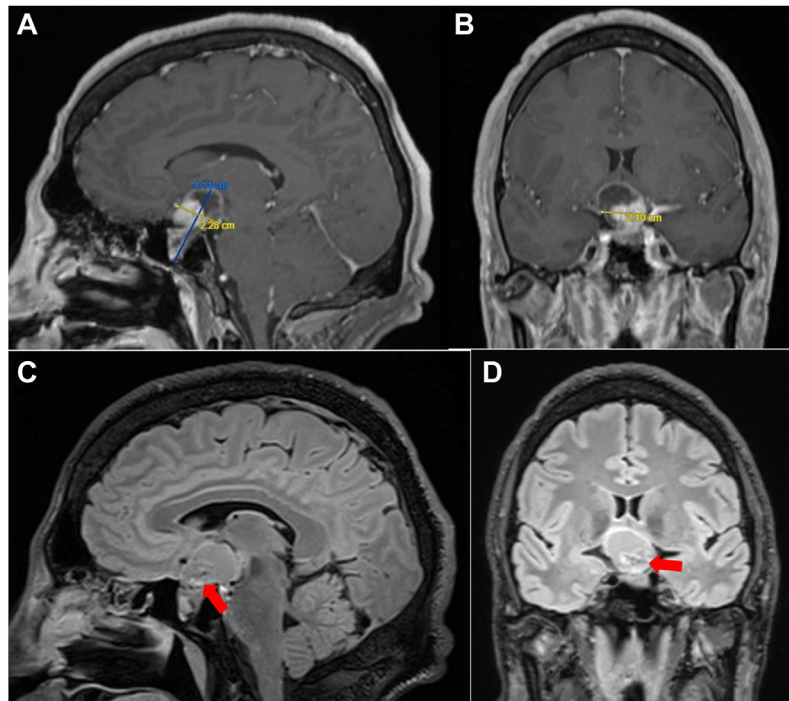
MRI brain with and without intravenous contrast, dedicated pituitary protocol. There is a mixed solid and cystic sellar/suprasellar mass which measures $4.1 \times 2.3 \times 2.1$ cm on postcontrast T1-weighted fat-suppressed images as seen in (A) sagittal and (B) coronal view. There is a solid avidly enhancing component that measures $1.6 \times 1.6 \times 1.6$ cm at the anterior inferior aspect of the lesion (red arrow) as seen on T2/FLAIR images in (C) sagittal and (D) coronal view.
